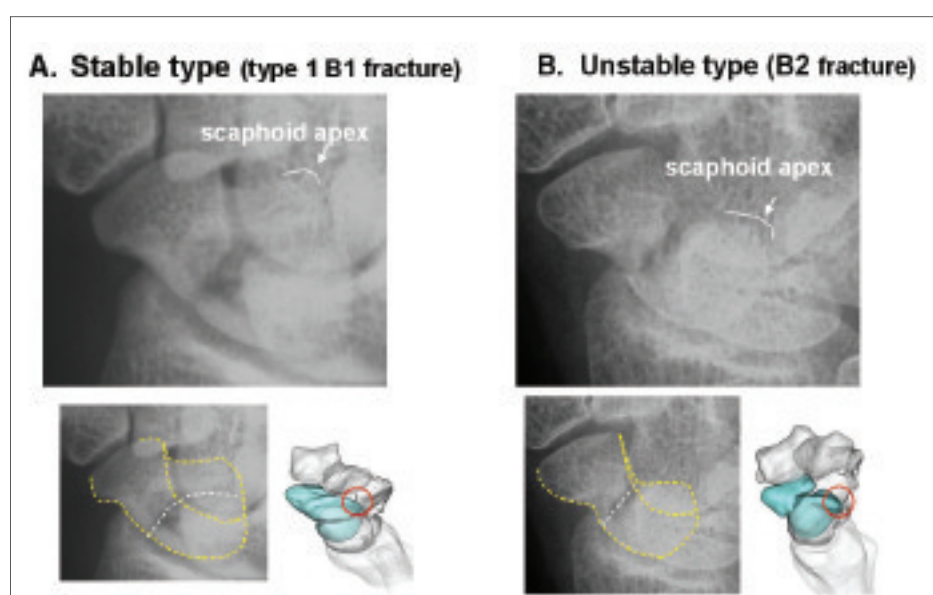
Oblique view X-ray and 3-D images of two patients with A) type 1 B1 and B) B2 scaphoid nonunion. Despite relationships between fracture line and the scaphoid apex are completely different, fracture lines on the scaphoid body on the x-ray look similar.
